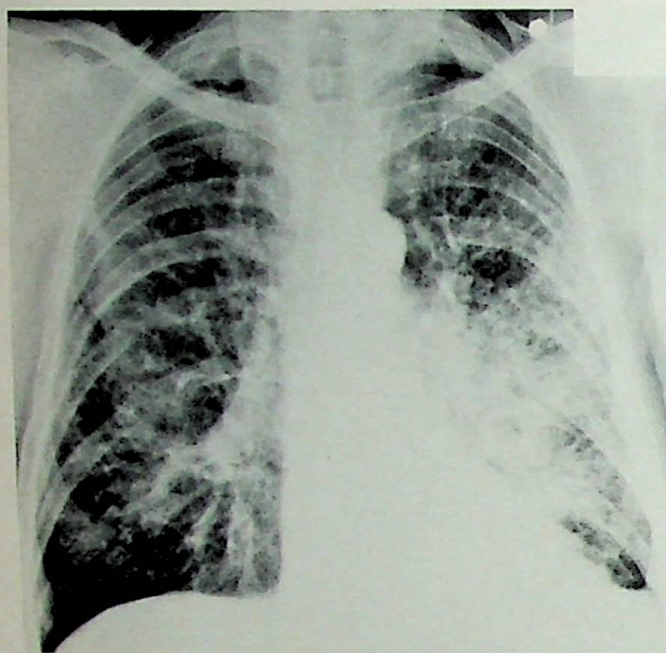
Roentgenographic demonstration of localized infiltrate in left lower lobe of patient with Churg-Strauss syndrome originally thought to be Löffler's syndrome.
